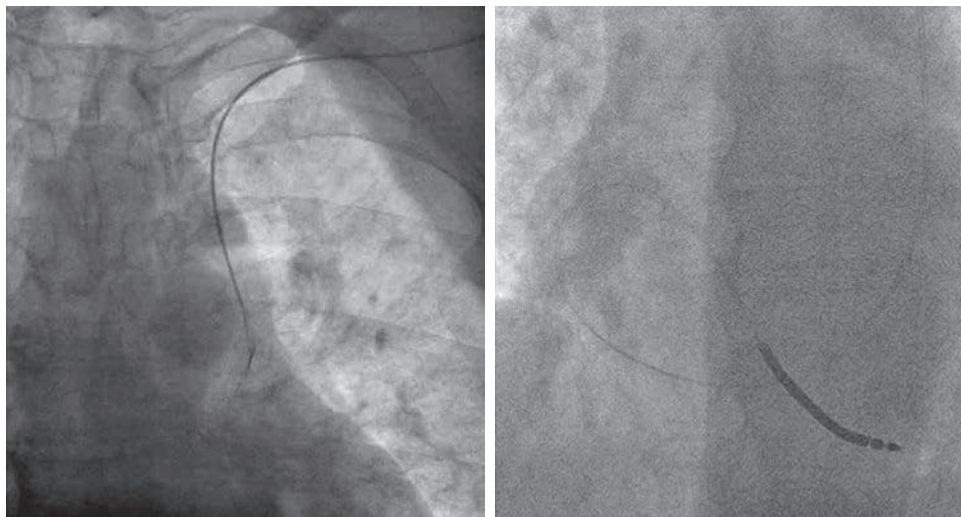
Persistent left-sided superior vena cava. This patient was listed for implantable cardioverter-defibrillator (ICD) implantation. The procedure started from the left infraclavicular region, as normal, but after obtaining axillary venous access, the guidewire was seen to pass inferiorly to the left of the spine, indicating a persistent left-sided superior vena cava (SVC; left X-ray), which was confirmed with contrast venography (not shown). The implanter elected to attempt insertion of a single coil defibrillator lead via the coronary sinus using a variety of shaped stylets, which was successful (right X-ray, right ventricular [RV] lead looped in the right atrium to cross the tricuspid valve).
